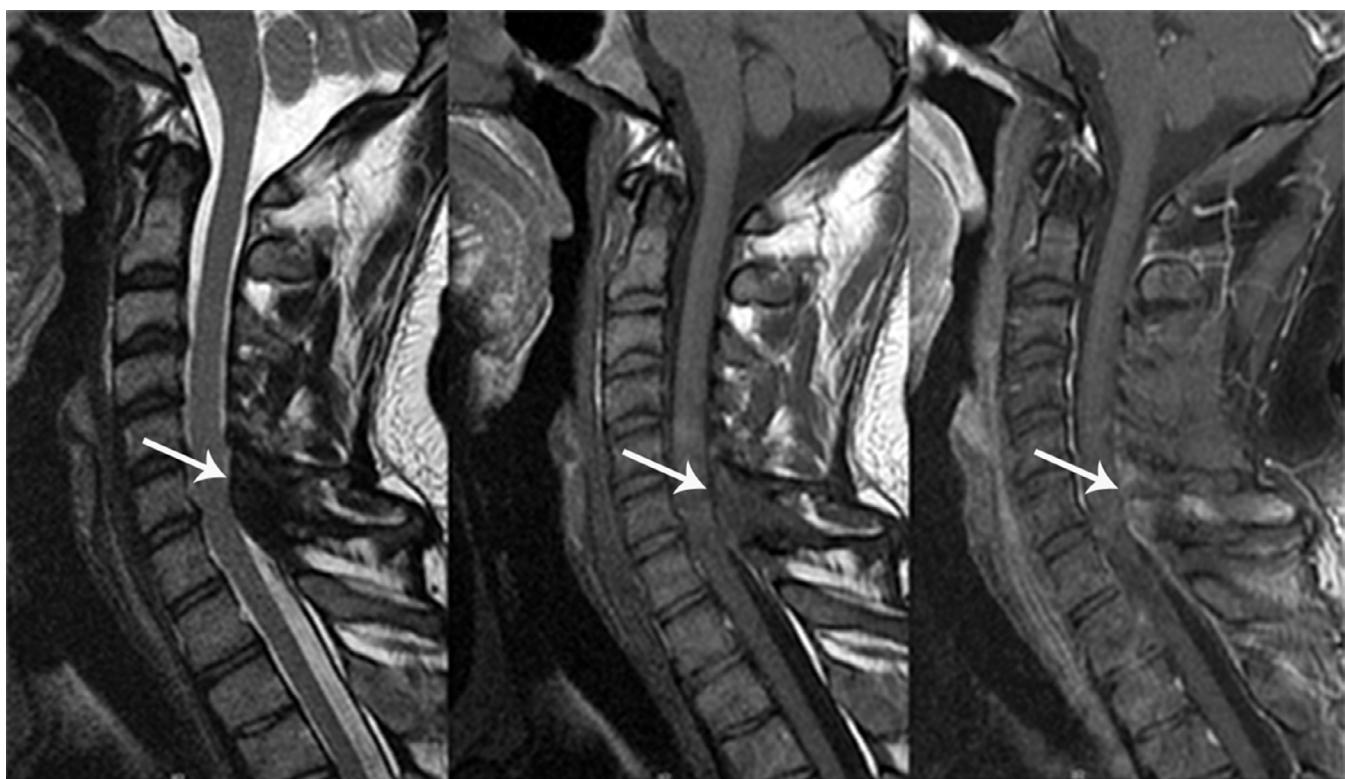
Sagittal T2-weighted MR images of the cervical spine through the level of C6 (Left, Middle, Right) showed a mass isointense to muscle on T1- and T2-weighted images with moderate enhancement (arrows).
